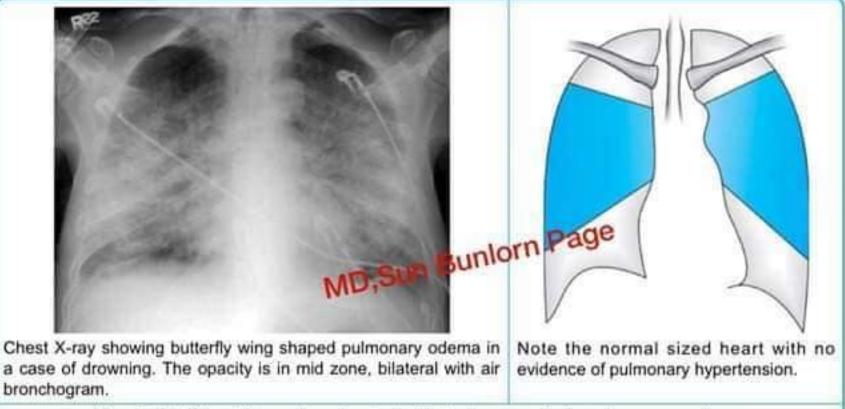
Chest X-ray showing typical batwing opacity in pulmonary edema
